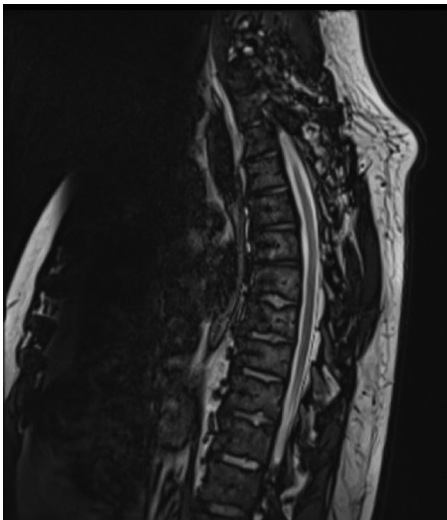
Sagittal T2-weighted magnetic resonance image showing the patient’s spinal column after laminectomy and antibiotic treatment. No further evidence of SEA is detected, indicating successful treatment. SEA, spinal epidural abscess.
